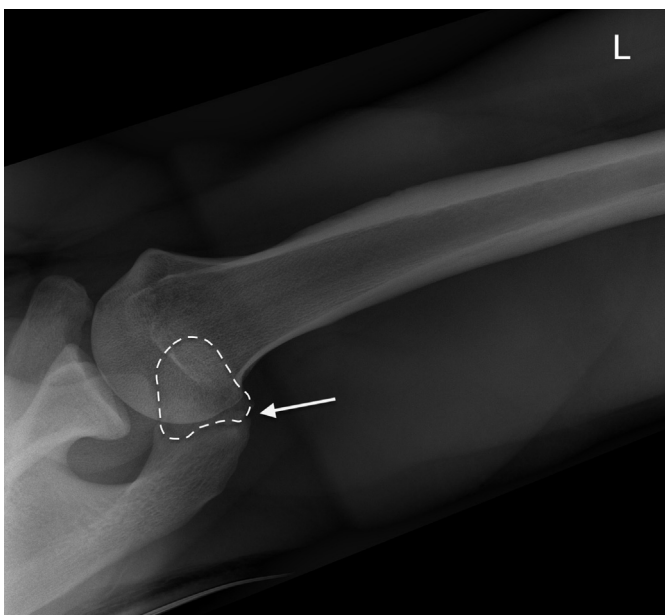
Axillary view radiograph of a left shoulder defines the neo-joint line (→) and the extension of the os mesoacromiale (- - -).
